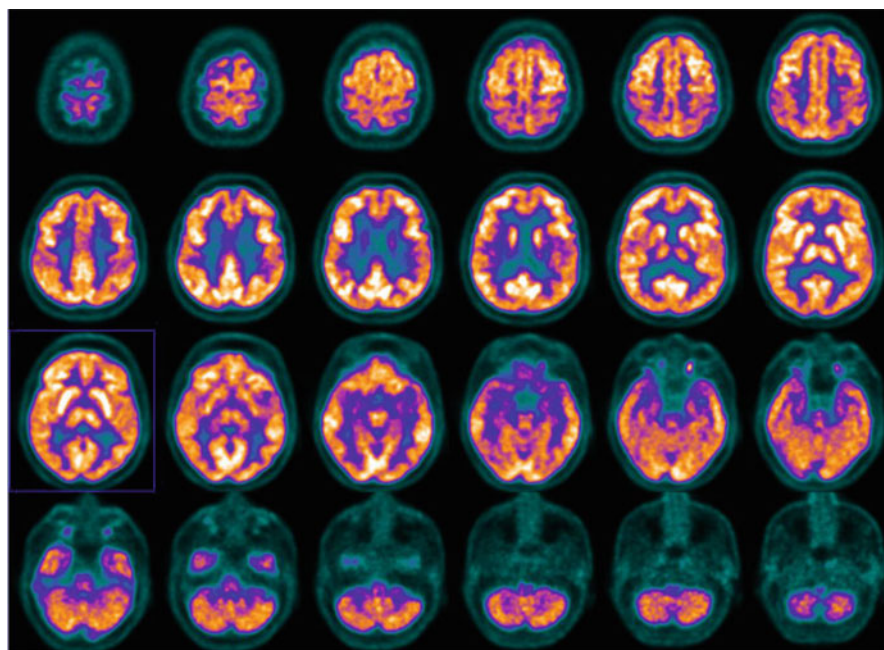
FDG-PET shows no significant alterations of the normal symmetric glucose metabolism of the brain
